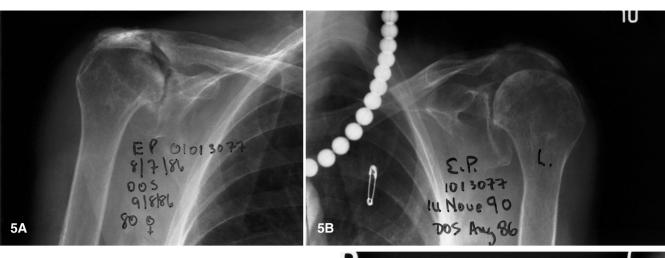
Case 5: a 80-year-old woman. A Right shoulder radiograph showing erosion of the glenoid and high riding of the eroded humeral head. Note pseudarthrosis between the humeral head, the acromion, and the clavicle. B Left shoulder radiograph showing mild erosion of the glenoid, the humeral metaphysis, and upward displacement of the eroded humeral head. Contour defects of the distal clavicle and acromion are present
